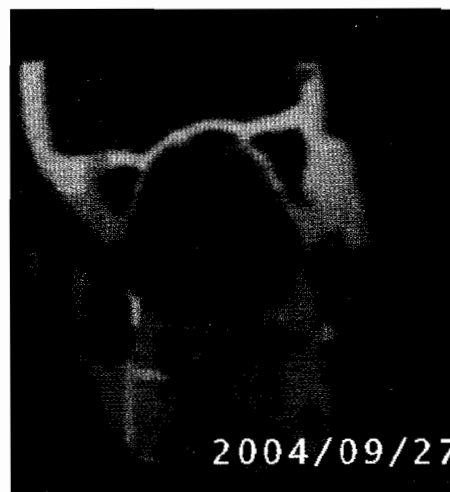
CT Scan coronal section (soft tissue window) showing big soft tissue mass occupying whole nasal cavity, bilateral maxillary and ethmoidal sinuses and extending to sphenoid sinus
